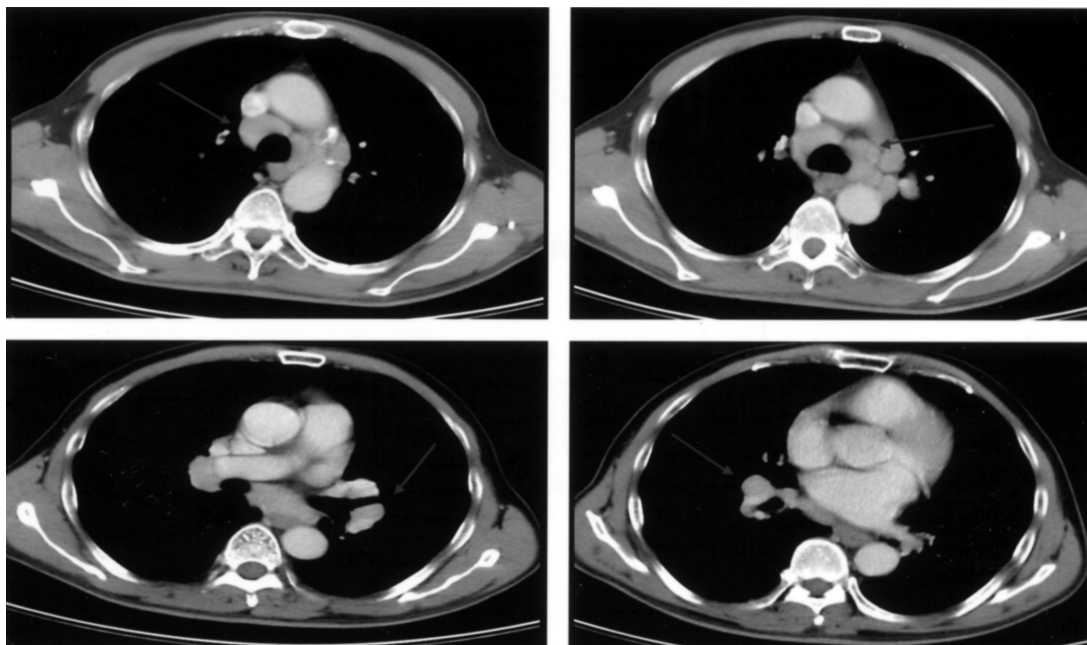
Computed tomography of the chest revealing multiple lymphadenopathies in the mediastinum and bilateral hilar regions (red arrows)
